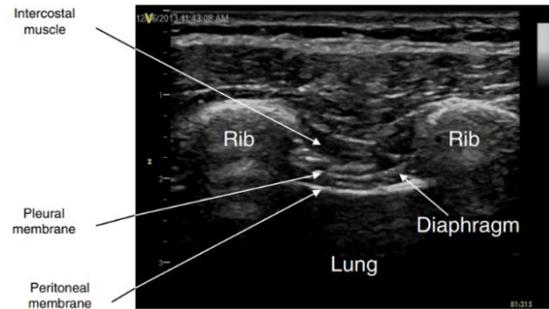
Ultrasonography visualization of a normal diaphragm by Orde et al. (20), measured in the zone of apposition at the right anterior axillary line, at approximately the ninth intercostal space using a linear array transducer in M-mode.
